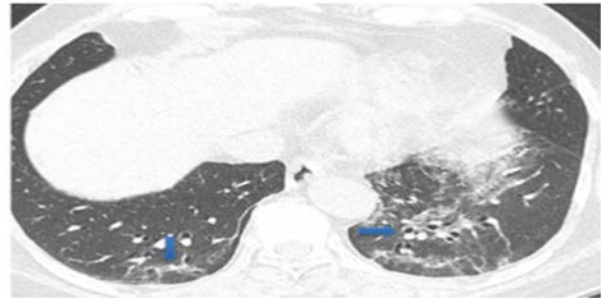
A male patient of age 85 presented with fever showing bronchiectasis (block arrows) and fibrosis (down arrow) in lower lobes of chest CT
